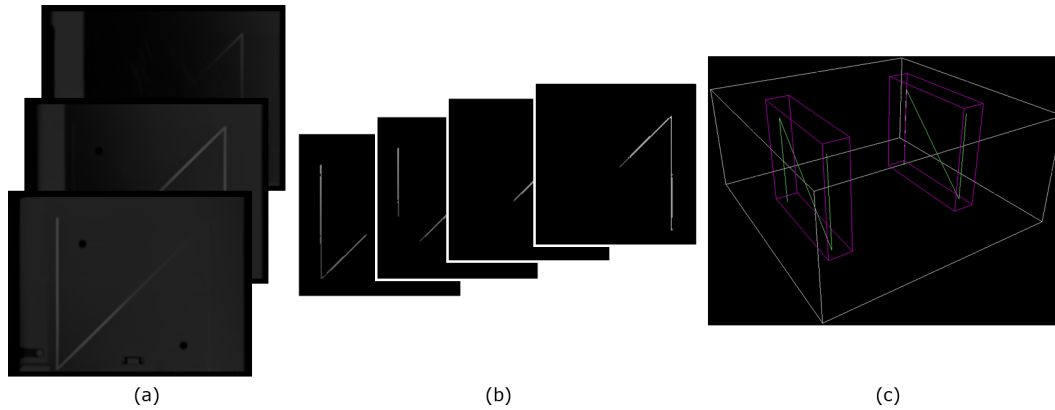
(a) The preoperative CT imaging data includes information of the stereotactic frame used as a base coordinate system for the procedure. (b) By focusing on the most considerable quantities in the data set, it is possible to extract the structures of the frame. (c) The system uses the extracted information to locate the position of the MER electrode during the placement process.
